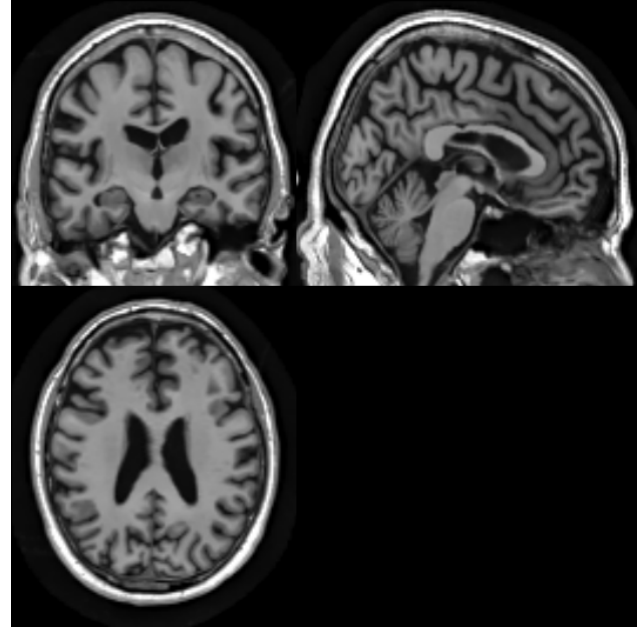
Structural MRI of the 007-S1206 NC subject from the ADNI dataset
